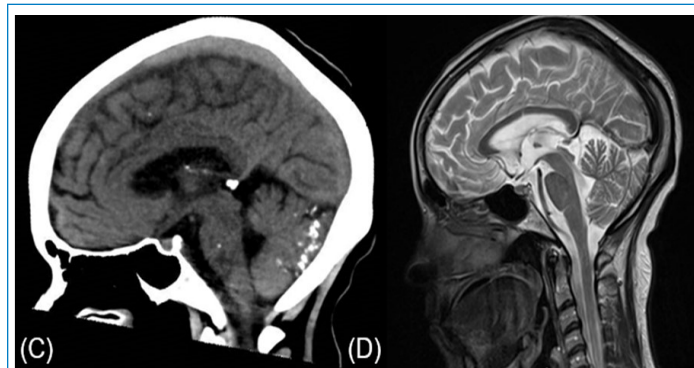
Calcifications seen in cerebellum. (C) Sagittal Brain CT, (D) Sagittal MRI T2 sequence. CT visualization superior to MRI.
